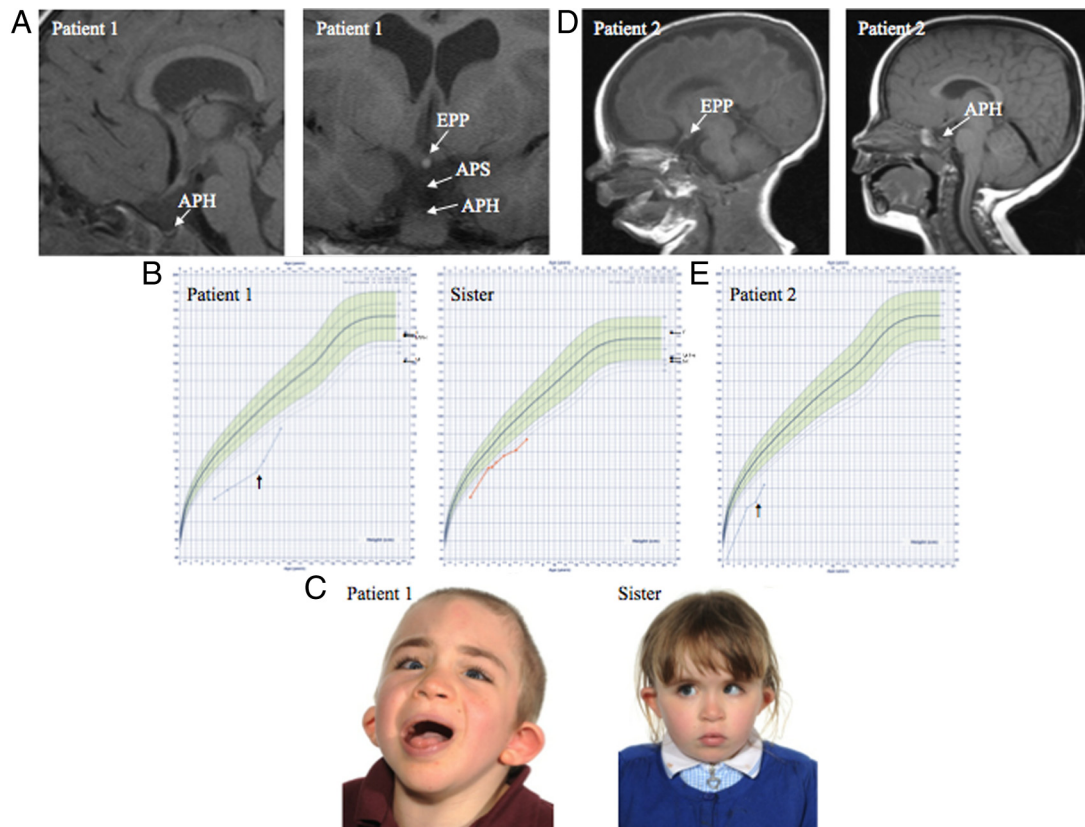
A, MRI in patient 1 revealed APH, an absent pituitary stalk (APS) with an undescended/EPP at the tuber cinereum and a thin corpus callosum. B, Growth chart for patient 1 and the sister of patient 1. Patient 1 presented with short stature at the age of 3 years and was commenced on GH at 7 years of age (left arrow). The sister of patient 1 was found to be GH deficient at 6 years of age. F, father; M, mother; MPH, midparental height. C, Photographs of patient 1 and his sister. Left, Patient 1 with probable/possible CHARGE syndrome according to Blake criteria. Right, The sister of patient 1 with an atrial septum defect (APS), abnormal ear, squint, developmental delay, and GHD. D, MRI of patient 2 at 2 months (left) and 20 months of age (right) revealed APH and an APS with an EPP at the tuber cinereum, bilateral colobomata, and underdeveloped frontal lobes. E, Growth chart of patient 2. Patient 2 presented with short stature at the age of 3 years and has recently been commenced on GH treatment at the age of 3 years (arrow).
